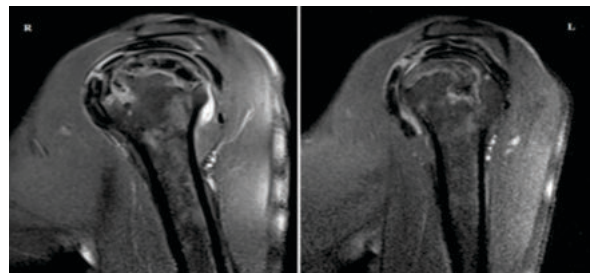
MRI of both shoulders showing osteonecrosis.
